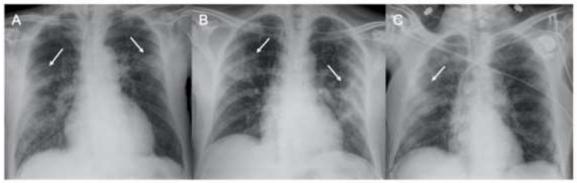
Chest X-ray in COVID-19 pneumonia. Three supine chest X-rays show subpleural consolidation (arrows), in (A, B) with bilateral involvement, and in (C) with primary involvement of the right lung.
